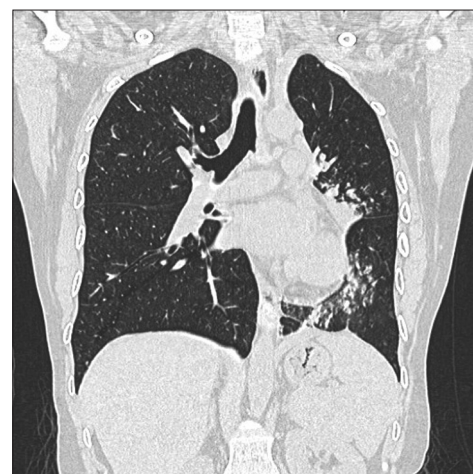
Post treatment CT Thorax showing aeration of upper and lower lobe with persistent post obstructive collapse of the lingula
